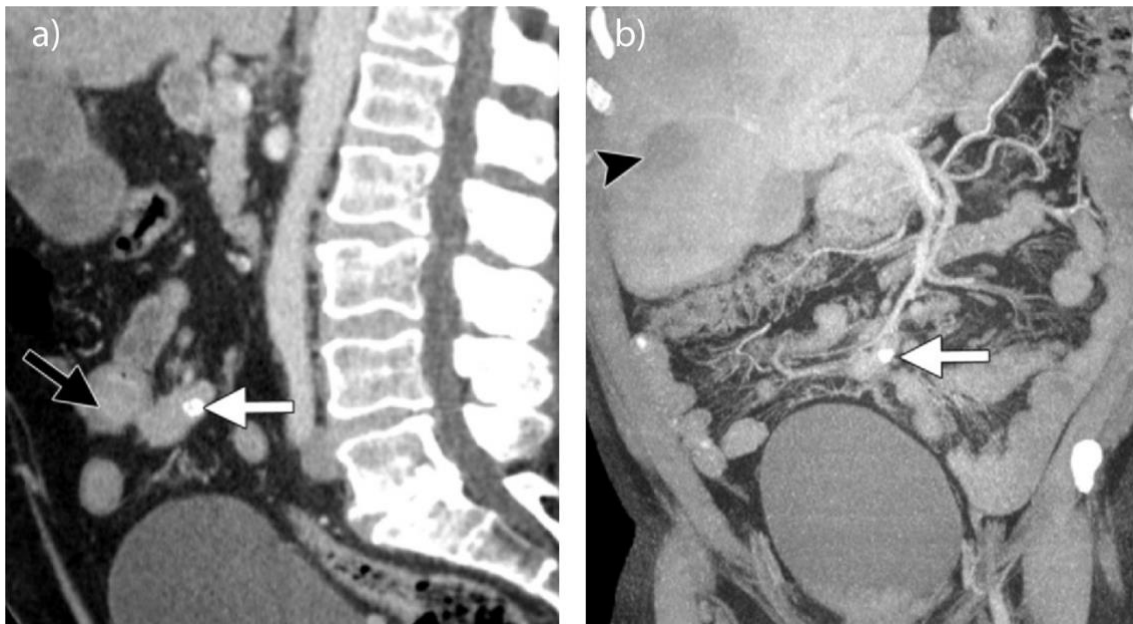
Contrast-enhanced CT of an ileal NET. Portal venous phase imaging. a) Primary tumor in a sagittal layer (black arrow) with calcified mesenteric nodes (white arrow), b) hepatic metastasis in a coronal layer (black arrowhead).^[18]
